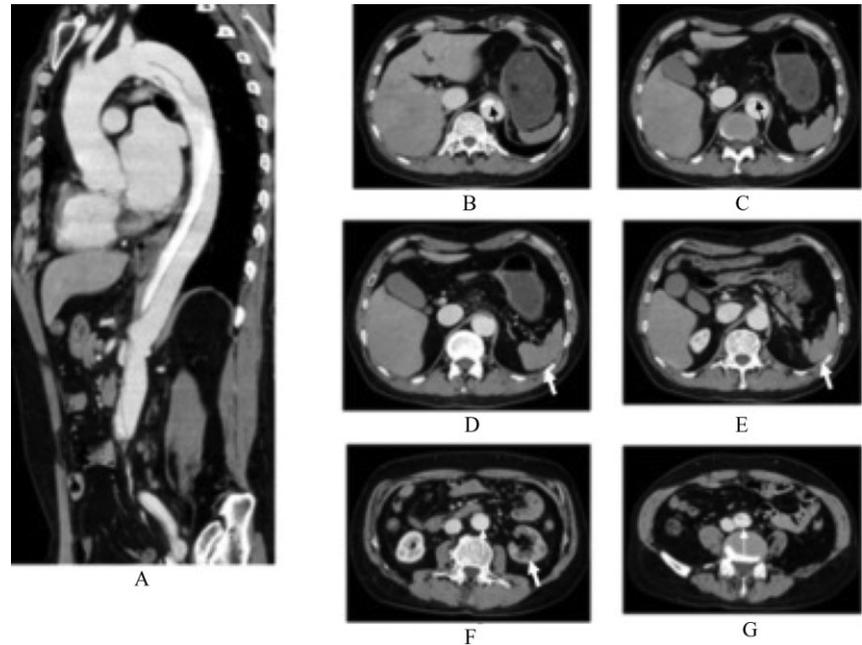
Preoperative chest and abdominal computed tomography in a 56-year-old man with sudden severe abdominal pain 13 days after the onset of type B acute aortic dissection. The intimal flap is seen to extend from the descending aorta to the abdominal aorta (A,B,C,G). The upper abdominal aorta is occluded by the false lumen (D). Blood flow through the celiac trunk and superior mesenteric artery is obstructed (E). Left kidney blood flow is diminished (F). Ischemic change is also seen in the spleen (B–E). Distal aortic blood flow via the false lumen is clearly seen (G).
